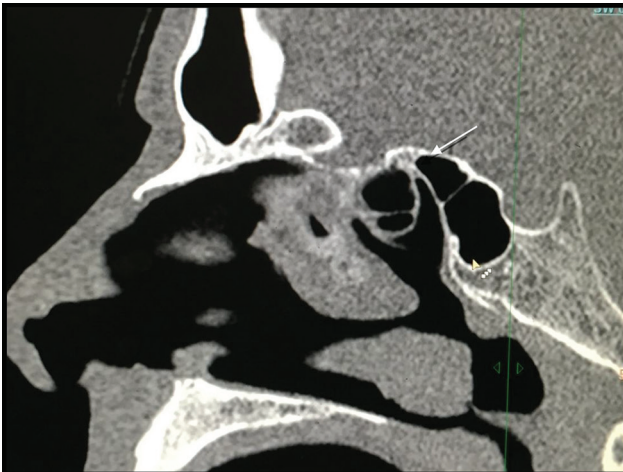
Coronal CT image of a 46-year-old male showing pneumatization of the anterior clinoid processes (white arrow).
